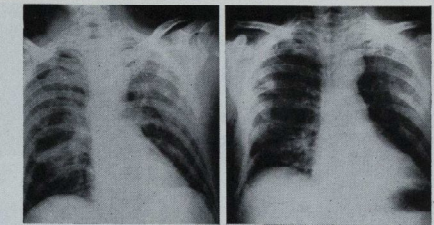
X-Rays of Case 2
